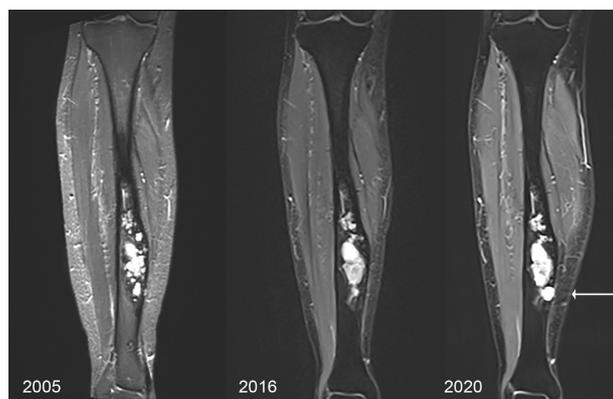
MRI T1 sequences show no significant change between 2005 and 2016. In 2020 in the distal region of the main lesion shows focal enlargement (arrow) and erosion of the cortex, which pathologically was diagnosed as AD in the curettage.
